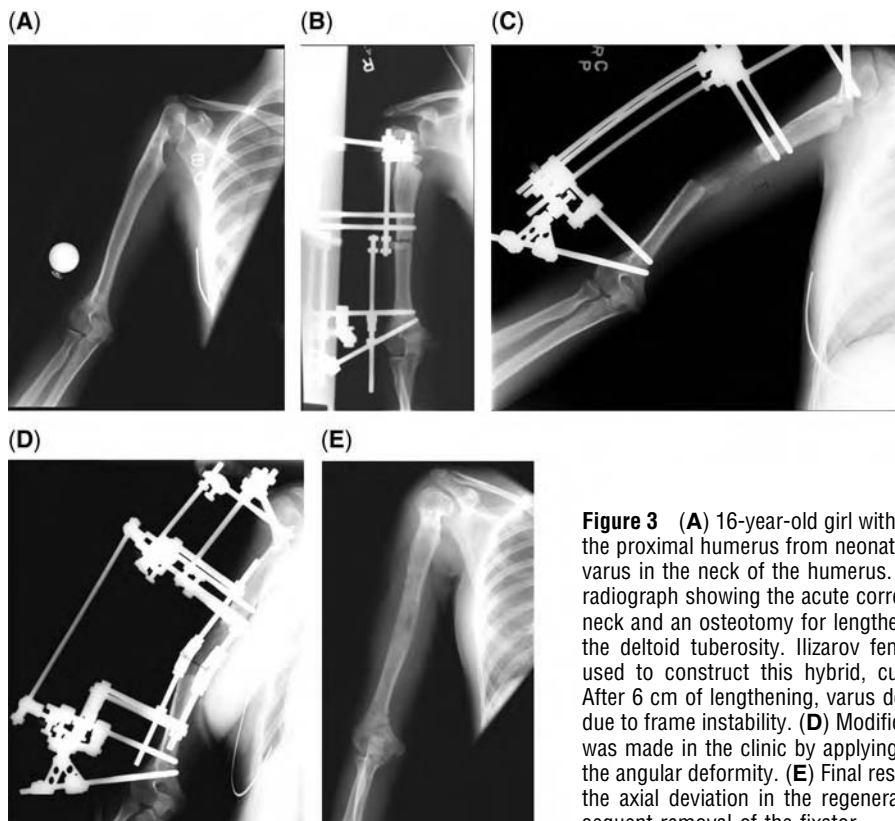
(A) 16-year-old girl with a growth arrest of the proximal humerus from neonatal sepsis. Note the varus in the neck of the humerus. (B) Postoperative radiograph showing the acute correction of the varus neck and an osteotomy for lengthening at the end of the deltoid tuberosity. Ilizarov femoral arches were used to construct this hybrid, custom fixator. (C) After 6 cm of lengthening, varus deviation developed due to frame instability. (D) Modification of the frame was made in the clinic by applying hinges to correct the angular deformity. (E) Final result after correcting the axial deviation in the regenerate bone and subsequent removal of the fixator.
